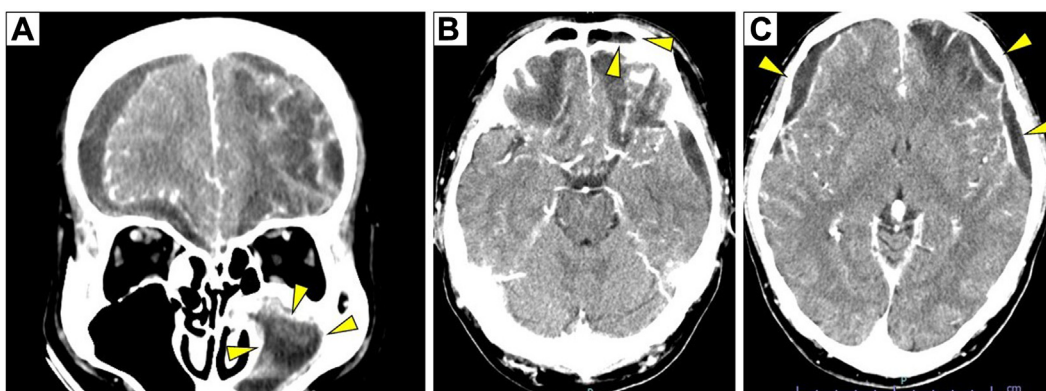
Contrast-enhanced computed tomography of the head. Contrast-enhanced computed tomography imaging demonstrates left-sided maxillary and frontal sinusitis (A, B), with evidence of multiple subdural abscess formations (C).
